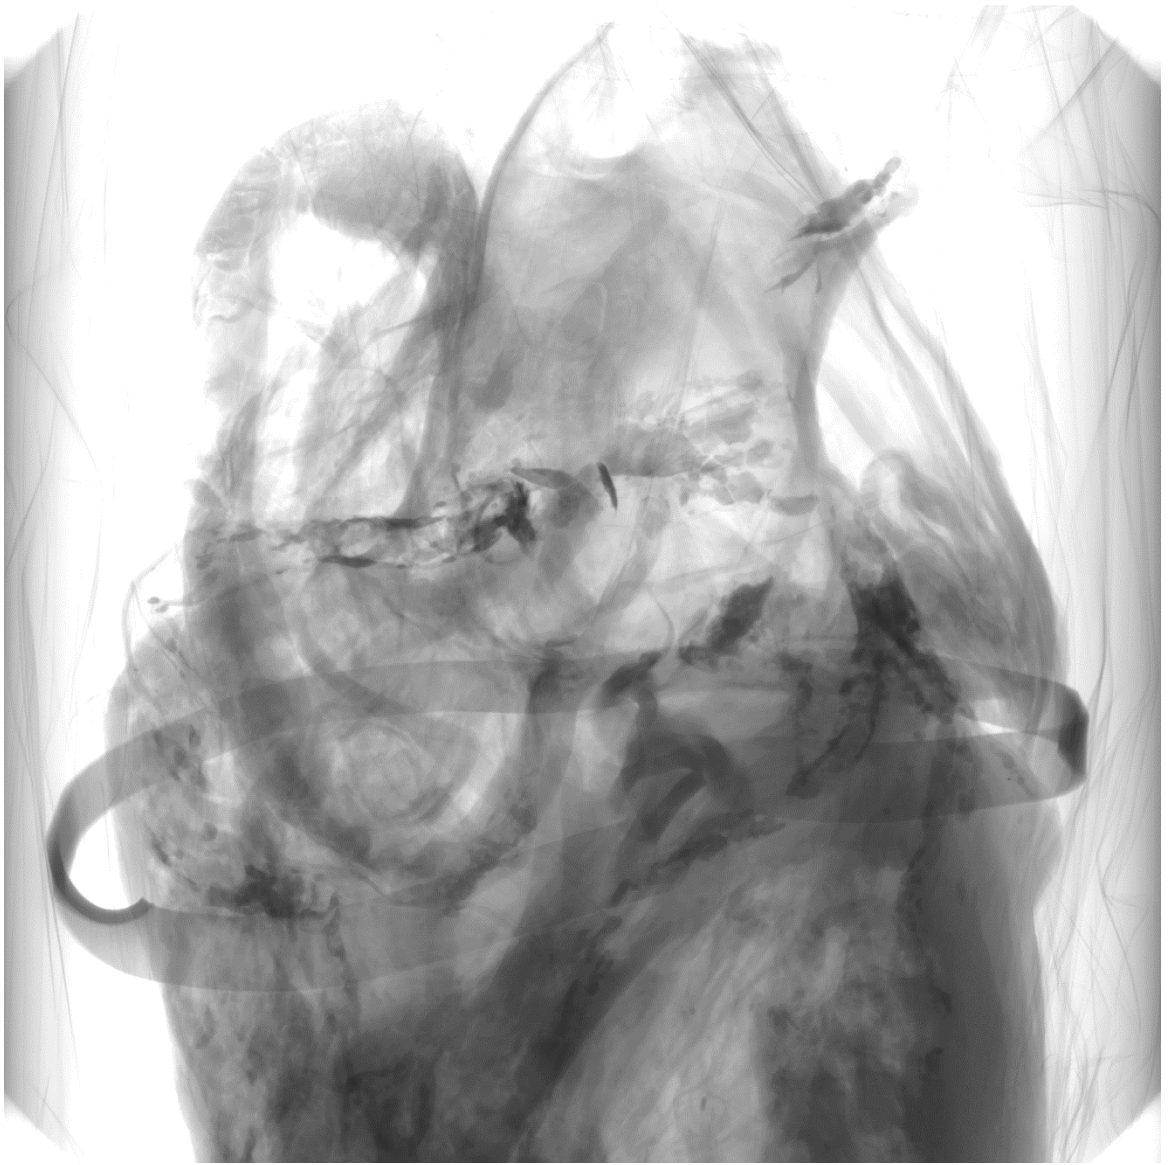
X-ray of a human heart taken using a μ CT scanner.
